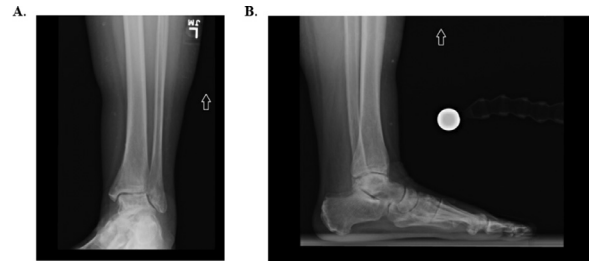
Preoperative plain radiographs. Mortise (A) and lateral (B) plain radiographs of the left ankle shows talar AVN
